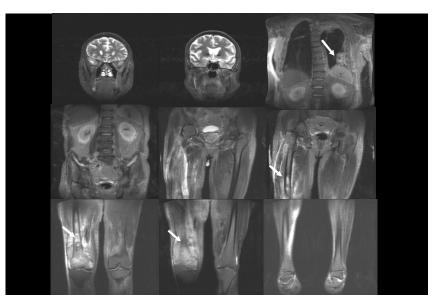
Whole-Body-MRI using a Turbo-STIR sequence was performed within 6 minutes indicating a lymphoma of the lung and of the right femur. These findings were proven by biopsy.
